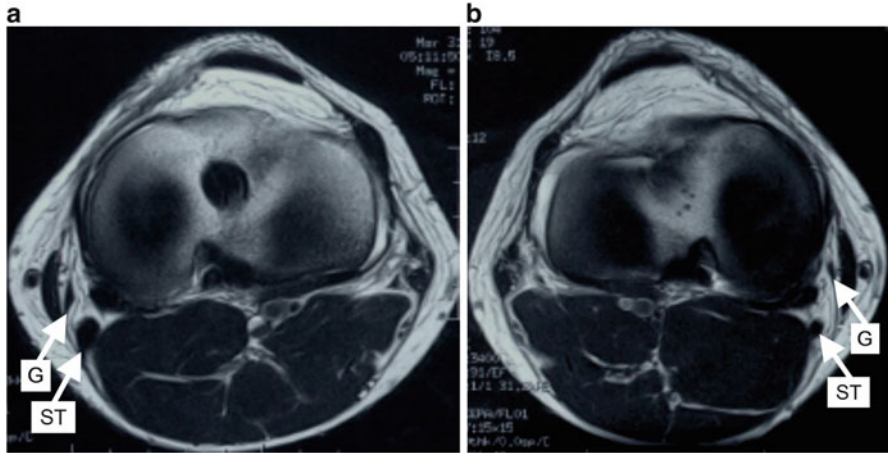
Axial MRI images demonstrating tendon regeneration following graft harvest (*ST*: semitendinosus tendon, *G*: gracilis tendon).
